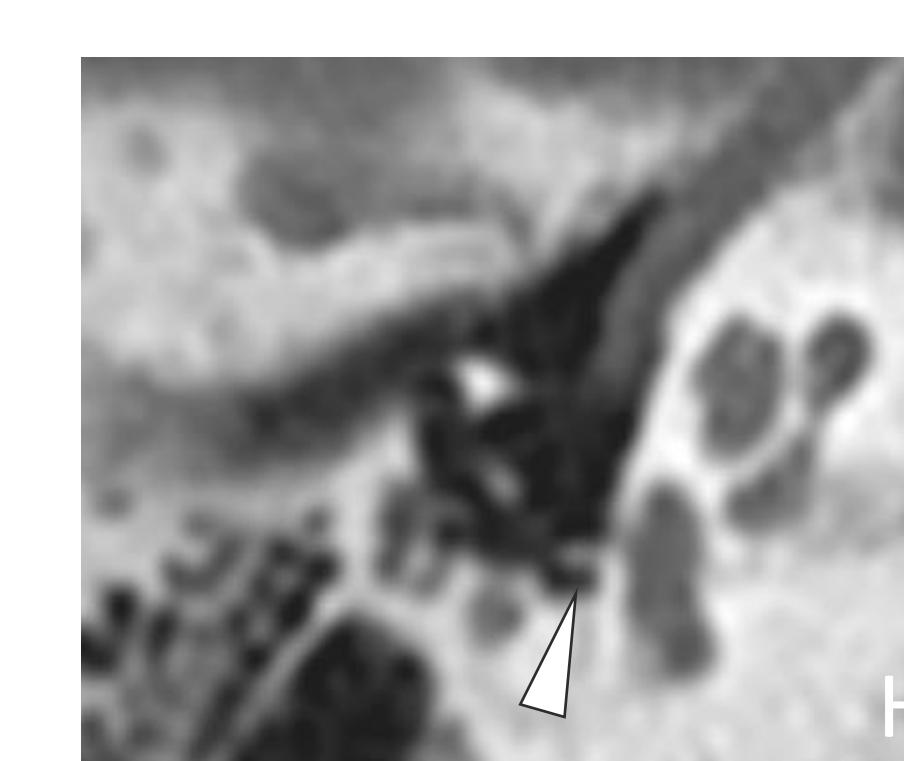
Axial CT of a patient with fenestral otosclerosis shows a monocrural stapes (arrowhead).
